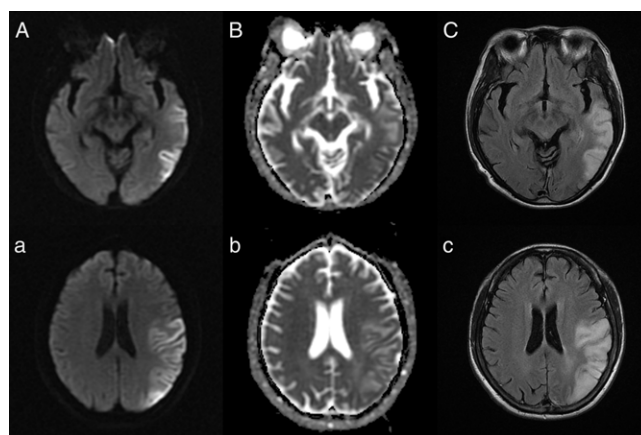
Axial brain magnetic resonance imaging during stroke-like episode. Diffusion-weighted imaging (A,a) shows cortical hyperintensity in the left temporal, parietal, and occipital lobes with cortical restricted diffusion on apparent diffusion coefficient map (B,b). T2-Fluid attenuated inversion recovery sequences (C,c) show cortical hyperintensity with edema and sulcal effacement in the same areas.
